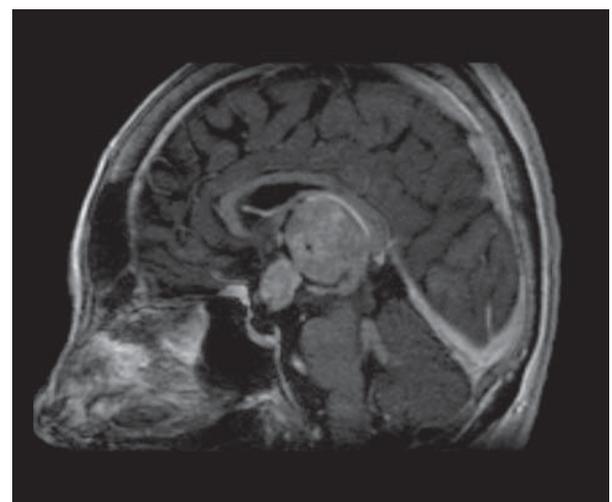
Post-gadolinium sagittal MR image showing heterogeneously enhancing mass occupying the third ventricle extending to the suprasellar recess and outlining the 4th ventricle.
